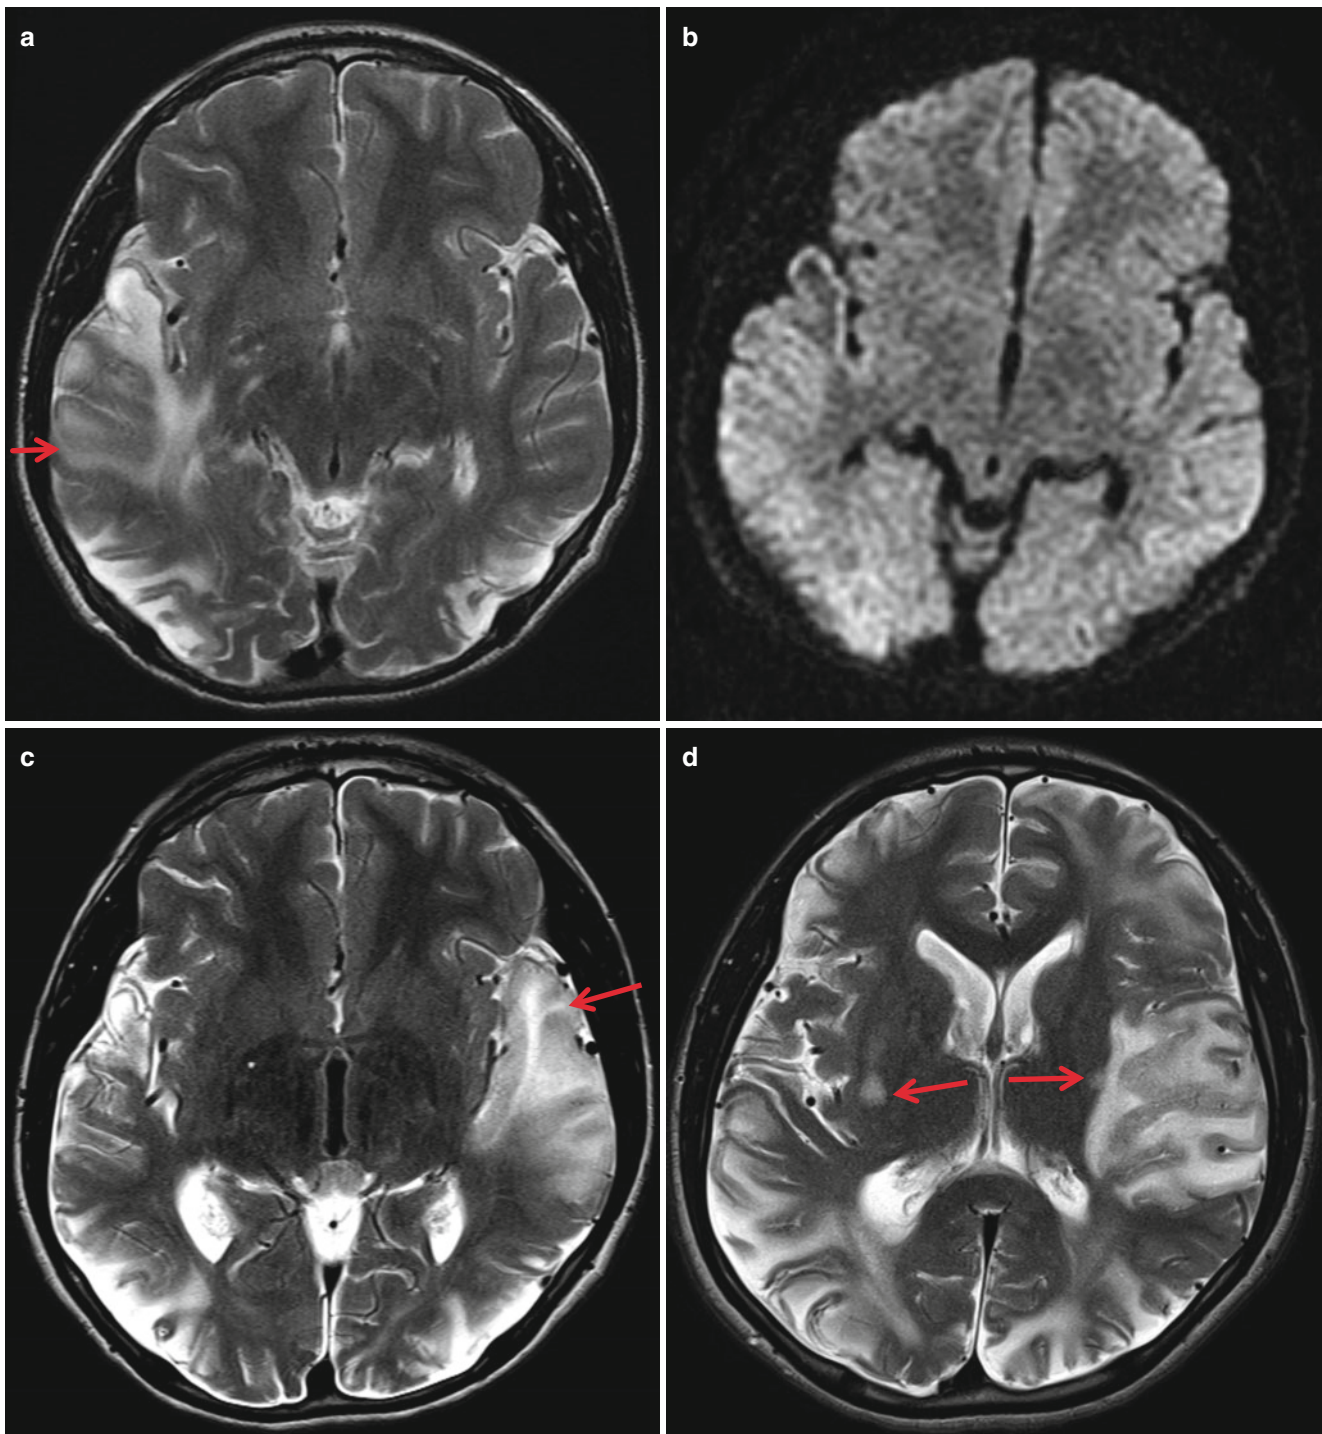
MELAS in an infant with multiple episodes of sudden visual disturbance and stroke. (a) T2-weighted image shows acute swelling in the right temporal lobe (*arrow*) and old cortical atrophy in both occipital lobes. (b) Diffusion image shows no remarkable diffusion abnormality in the right temporal lobe lesion. (c) Newly developed acute swelling
